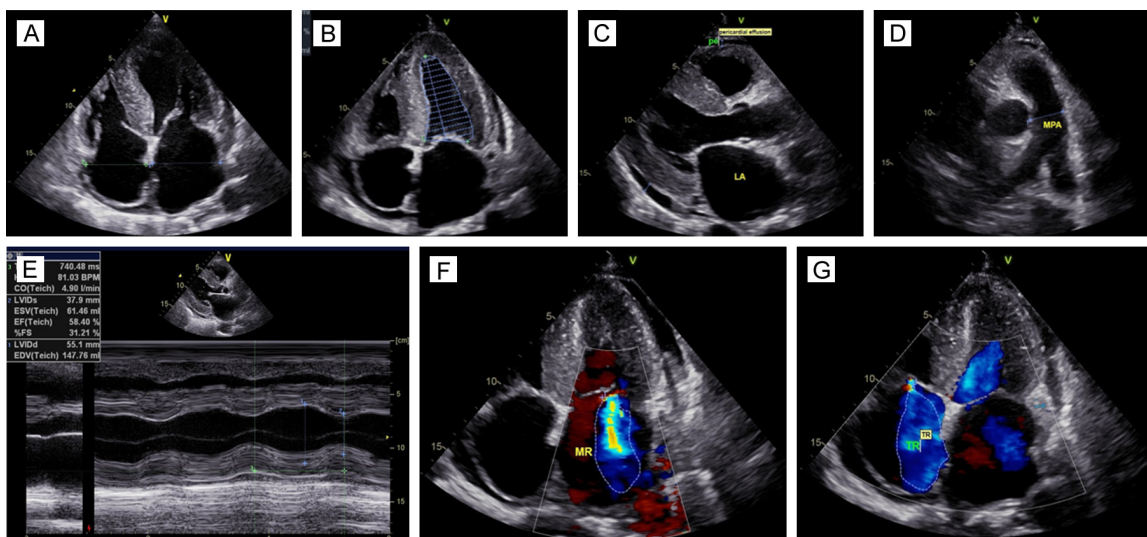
Typical representative legend of ultrasonic cardiogram (UCG) examination results of CA patients. The UCG showed: A: Left atrium and right atrium were enlarged, and left ventricular wall motion was weakened. B, C: Septum and posterior wall of left ventricle were symmetrically thickened, and the myocardium showed speckled strong echo. D: Widening of pulmonary artery and pulmonary hypertension. E: M pattern echocardiographic ventricular wave cluster showed significant thickening of the ventricular septum and the posterior wall of the left ventricle. F, G: Mitral regurgitation (moderate to severe) and tricuspid regurgitation.
